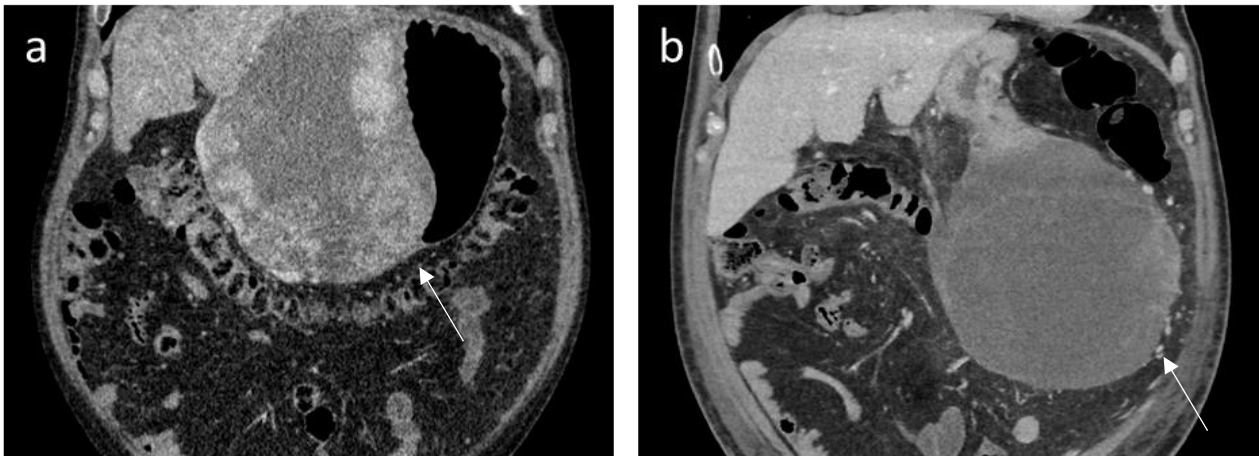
Coronal portal venous phase CE-CT images of an 86-year-old male diagnosed with a gastric GIST (arrows). a) Before treatment induction, the origin of the tumour was difficult to assess. As a result, the surgeon opted for a partial gastrectomy. b) After 1.8 months of TKI treatment, the tumour dimensions remained relatively unchanged. However, the improved visualisation of the area of tumour attachment to the stomach is imperative for surgical planning and oversight. Based on this information, a partial gastrectomy could be converted to a wedge excision.
